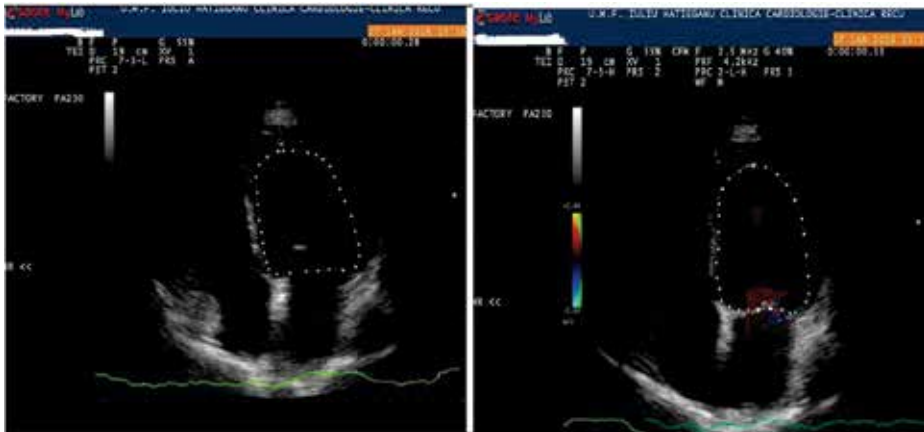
Echocardiography apical view before isolation of the pulmonary veins showing dilated left ventricle 65/55 mm with depressed ejection fraction of 30%, mitral regurgitation grade 2 and a dilated left atrium. Images after ablation at 3-month follow-up are not available.
